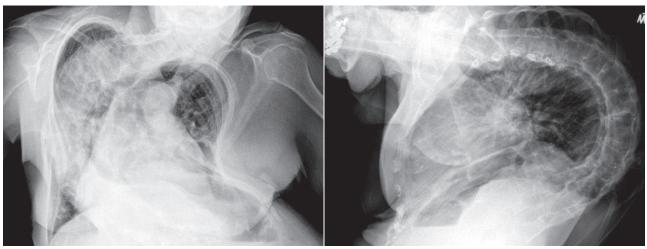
Frontal and Lateral Chest X-Ray Views of the Same Patient, Showing Severe Scoliosis and Kyphosis.
